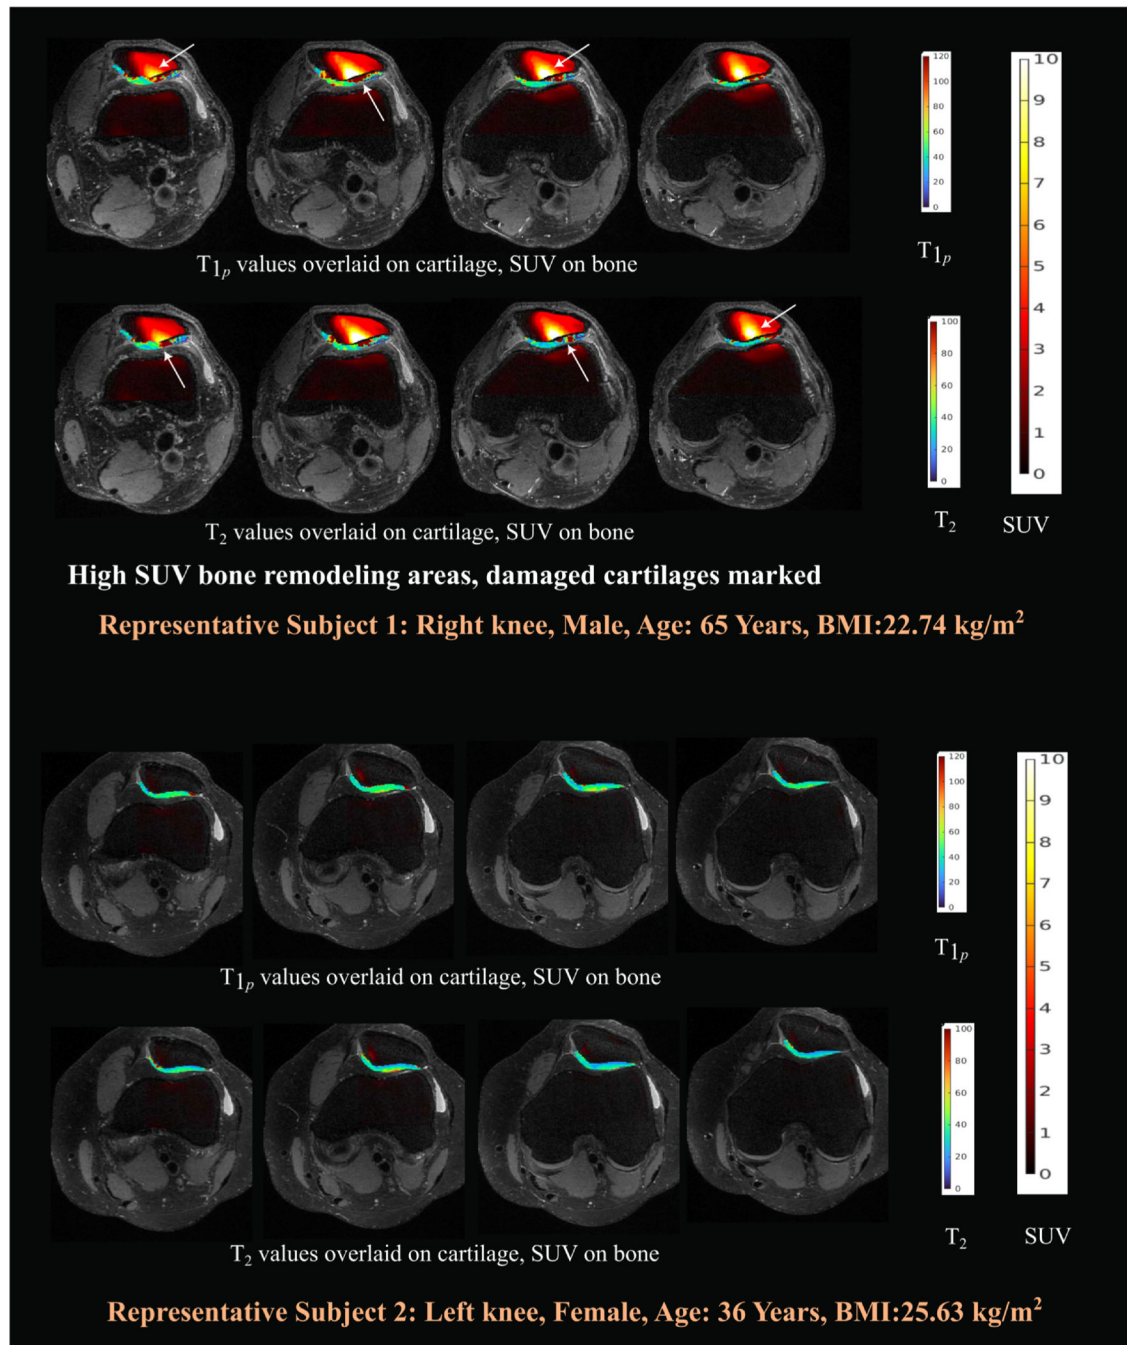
Demonstrative T_{1p} , T_2 , and SUV images of two subjects. Subject 1: Right knee of a Male (65 years aged) subject with isolated PFJ-OA. Subject 2: Left knee of a Female (36 years aged) subject with isolated PFJ-OA.
